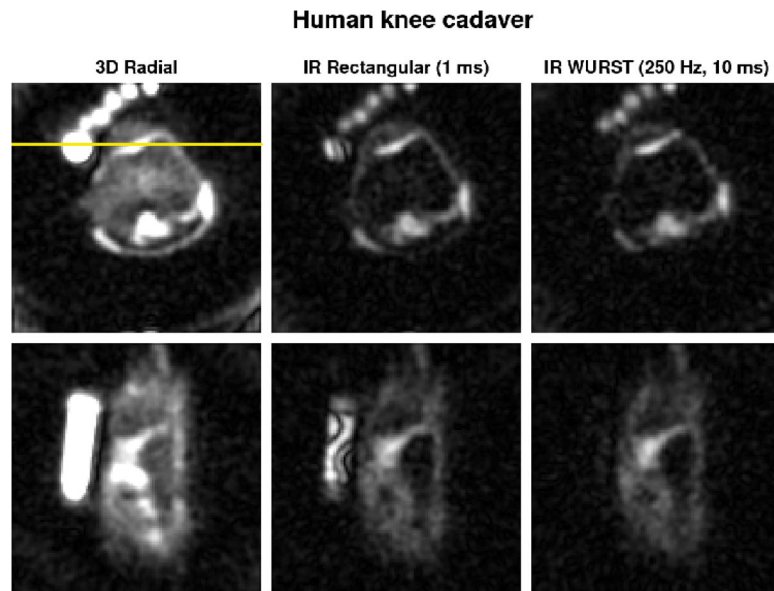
Transverse (top row) and coronal (bottom row) sodium MRI of the human knee ex vivo without and with IR (rectangular and WURST pulses). The images are averaged over 2 slices for better visualization. The same range scaling is applied to all the images. Human knee images were acquired with 10000 projections. The coronal slice was chosen to pass through the PBS tube in order to show the strong suppression inhomogeneities of the rectangular inversion pulse (horizontal yellow line). Note the uniform and complete fluid suppression with the WURST inversion pulse in the PBS tube and the very non-uniform fluid attenuation obtained with the rectangular pulse.
